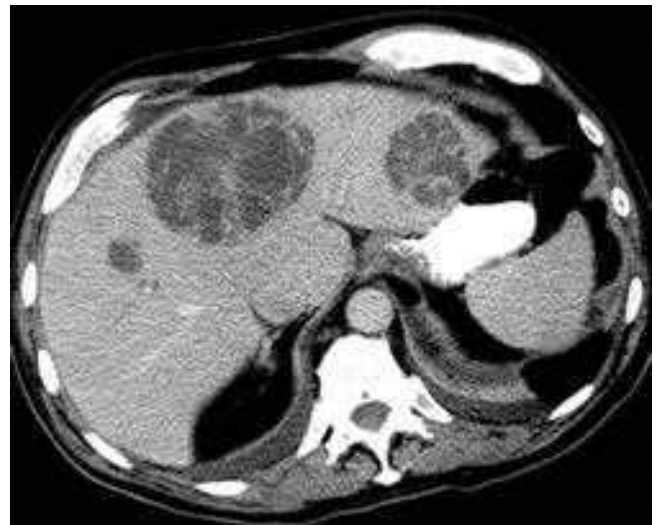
Computed tomographic scan of pyogenic liver abscesses. Multiple hepatic abscesses are seen in a patient after an episode of diverticulitis. Note the loculated large central abscess as well as the left lateral segment abscess.
